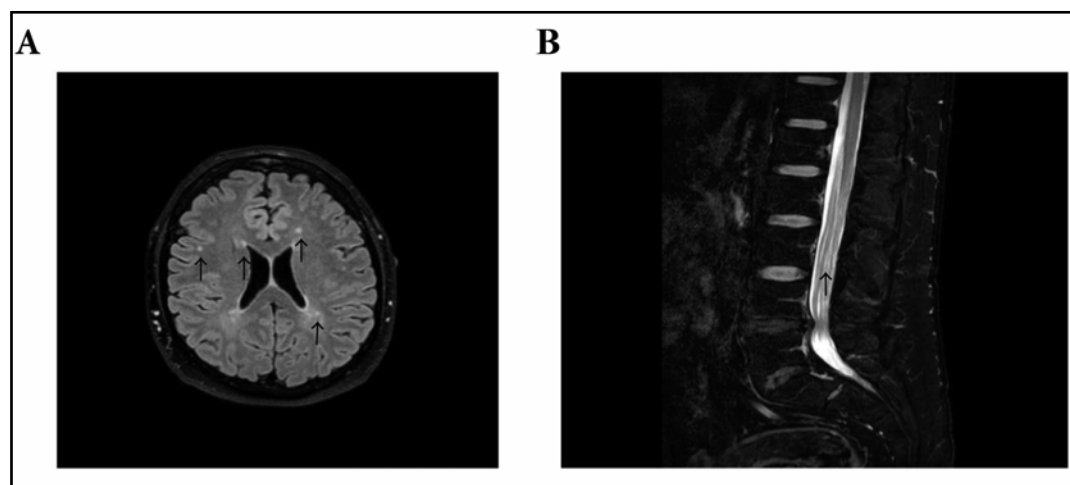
Baseline MRI of the brain: (A) Multifocal demyelinating lesions within the white matter of the brain 3 months before the admission (arrows); (B) Baseline MRI of the lumbar spinal cord: Pathologic enlargement and post-contrast enhancement of cauda equina at the time of admission
